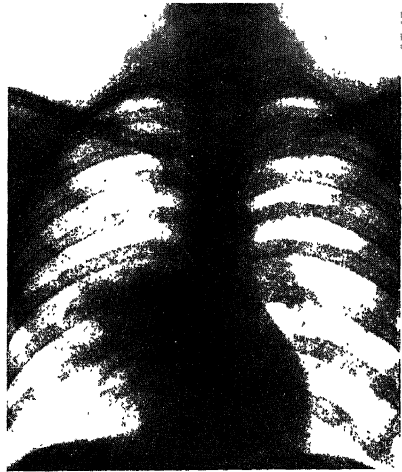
Atypical pneumonia. Note increased shadows in right hilum and outlining of vena azygos lobe. The lesion cleared within 10 days and the radiograph at this time was of a normal chest.
